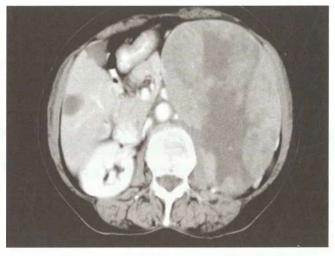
CT scan showing left RCC
